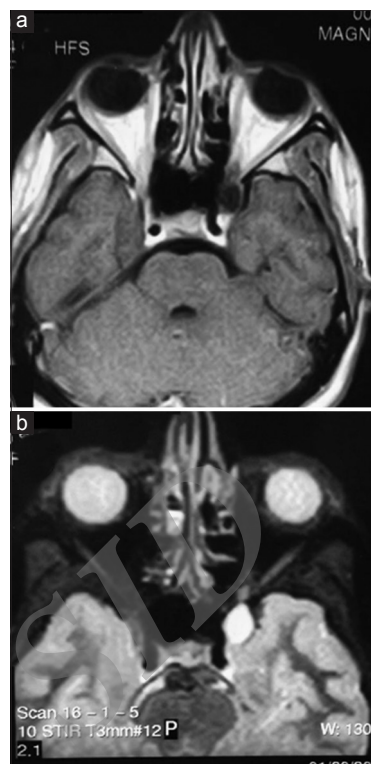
Axial MRI of the orbit; (a) post contrast T1 weighted image, (b) short T1 inversion recovery (STIR) image.
